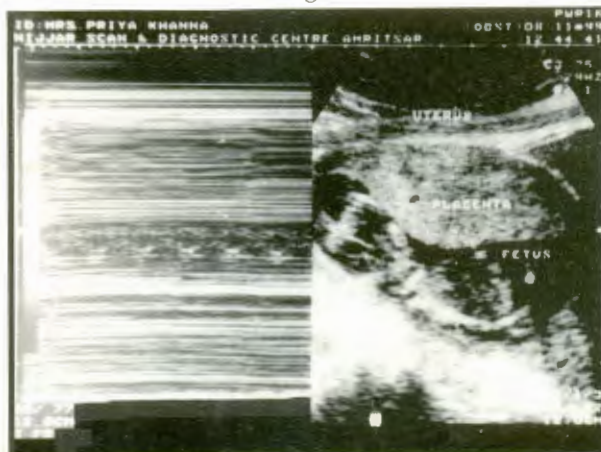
Ultrasound showing viable single foetus at 13 weeks and 4 days gestation.
